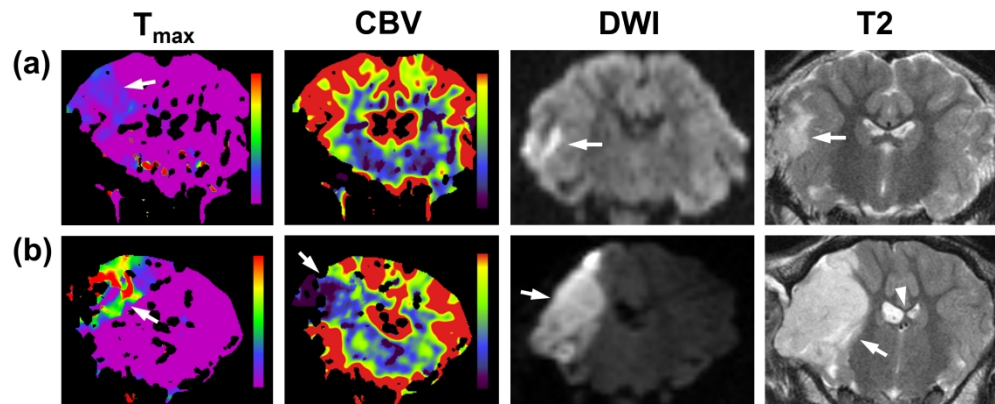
CT perfusion images during MCAO and consecutive evolution of infarcts on MRI.
